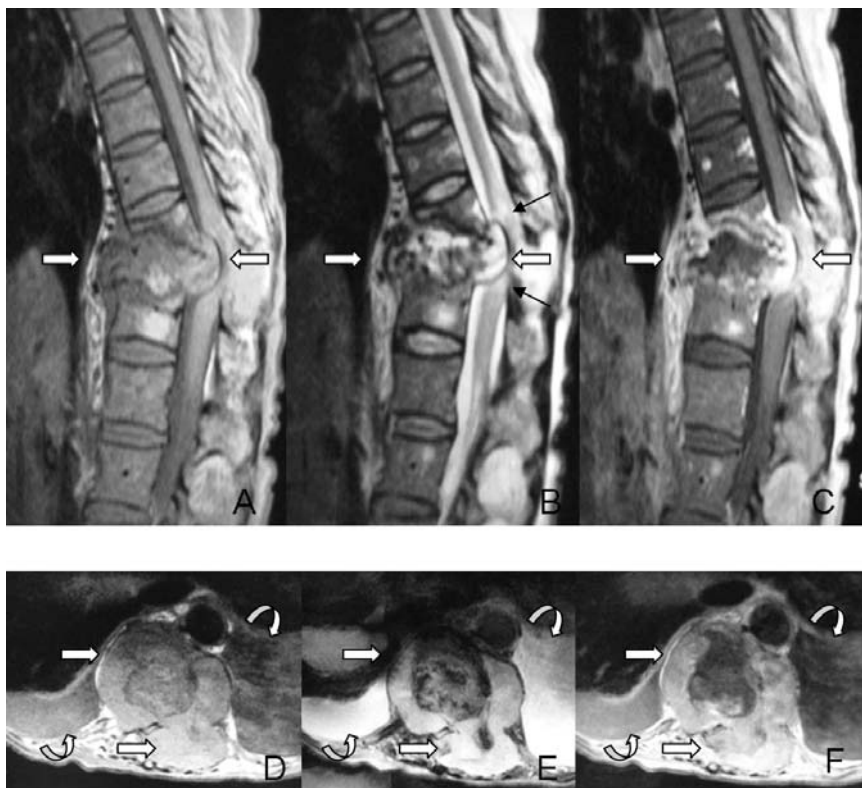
Spinal tumor (metastasis) was misdiagnosed as tuberculous spondylitis on MRI.
